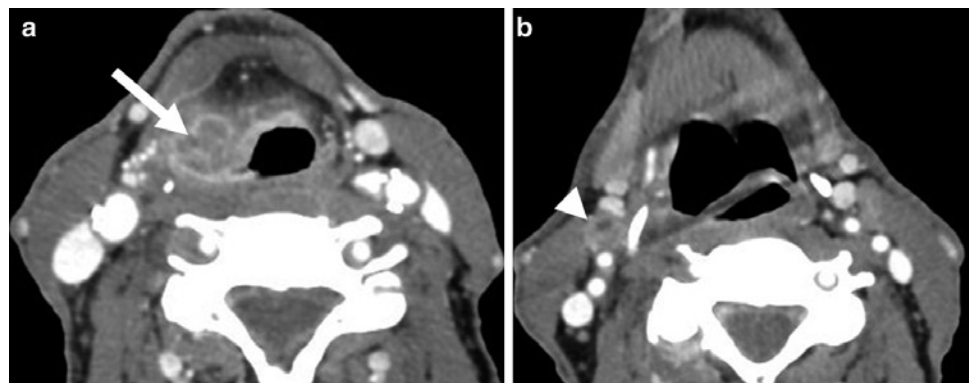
Axial postcontrast CT scan showing T3 stage right aryepiglottic fold carcinoma (a) with transglottic extension (arrow) and metastatic right level 2 lymphadenopathy (b) consistent with N1 disease (arrowhead)
